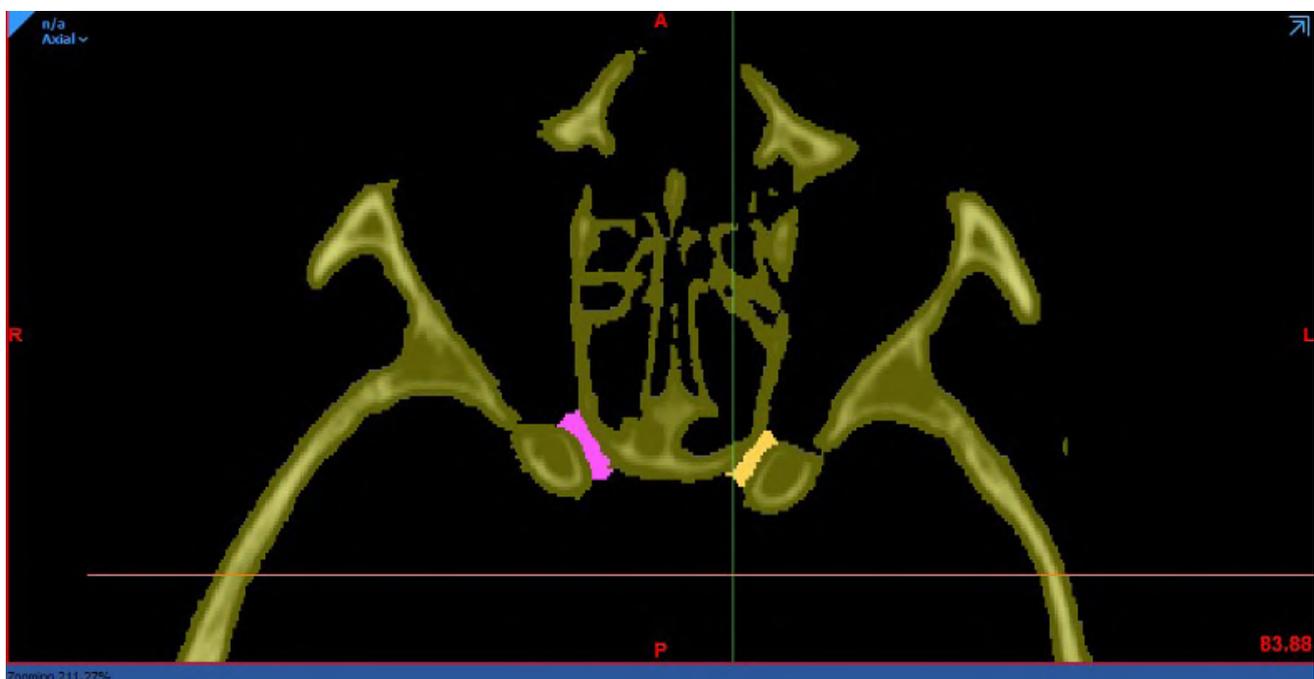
Measurement of the OC volume (mm³) in the axial section of the CT scan (Mimics 18.0 software - Materialise, NV, Belgium).
